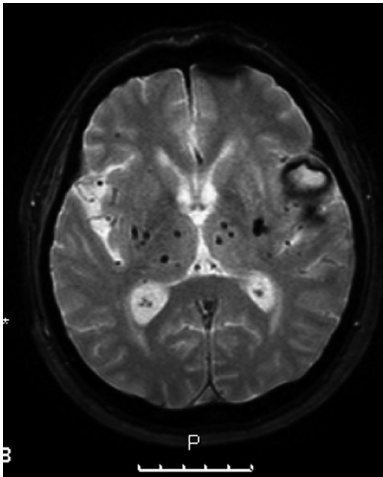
Gradient echo MRI showing multiple microbleeds (appearing as black spots) and a more recent left frontal cortical haemorrhage. © Anthony Pereira.
